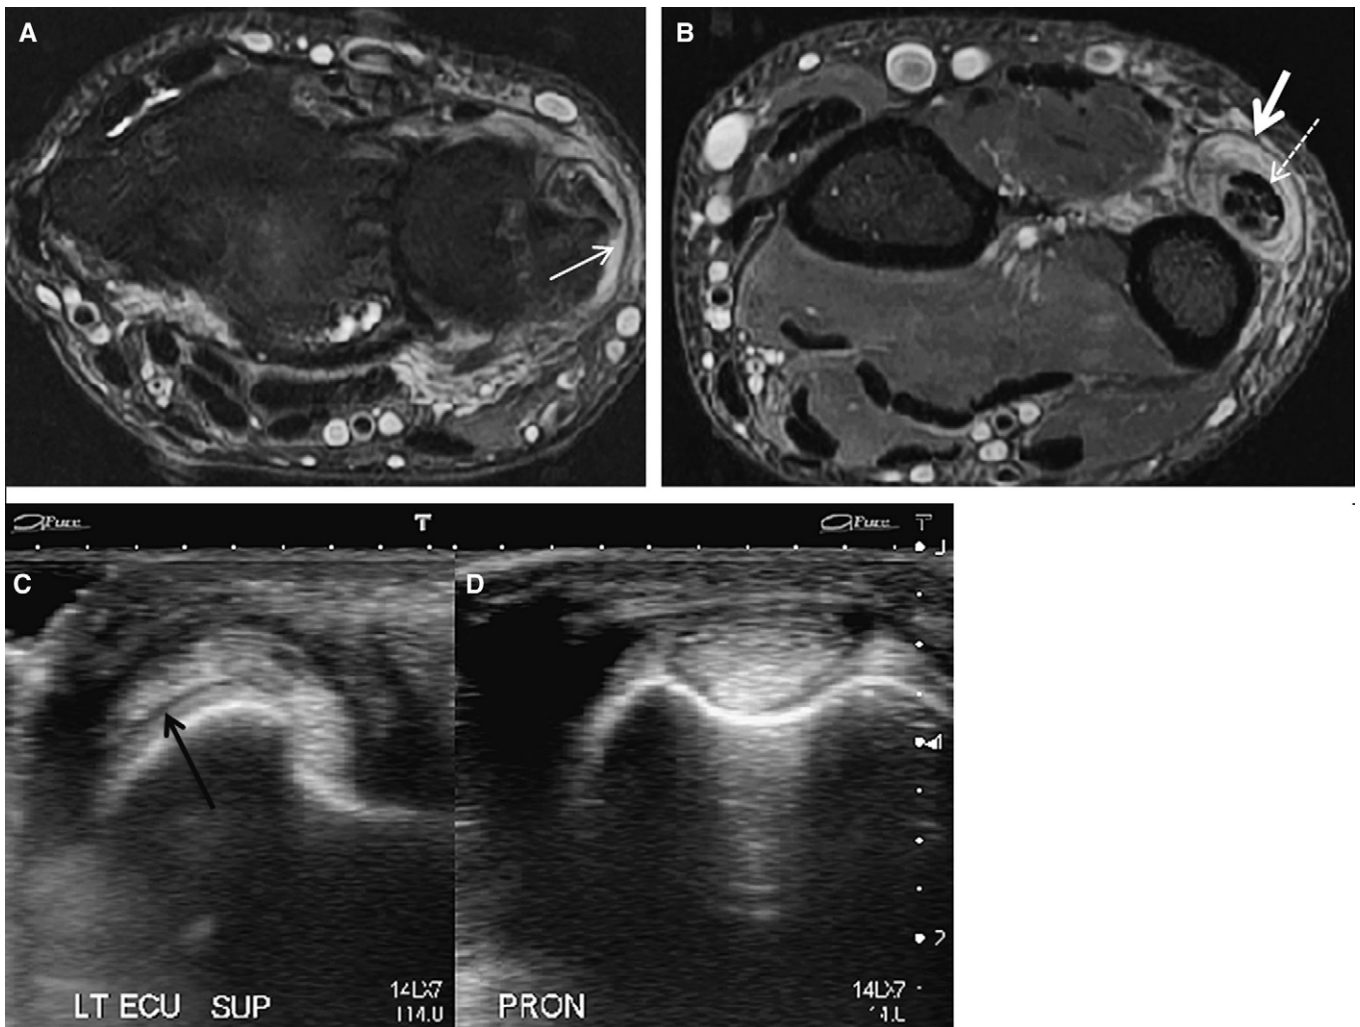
Extensor carpi ulnaris pathology. Axial proton density fat-saturated magnetic resonance images (A) and (B), demonstrating a tear of the volar aspect of the extensor carpi ulnaris (ECU) subsheath (thin white arrow). Notice the longitudinal split tears (dotted white arrow) and tenosynovitis (thick white arrow) that involve the ECU. In a different patient, transverse ultrasound images in supination (C) and pronation (D), demonstrating volar subluxation of the ECU during supination (black arrow).
